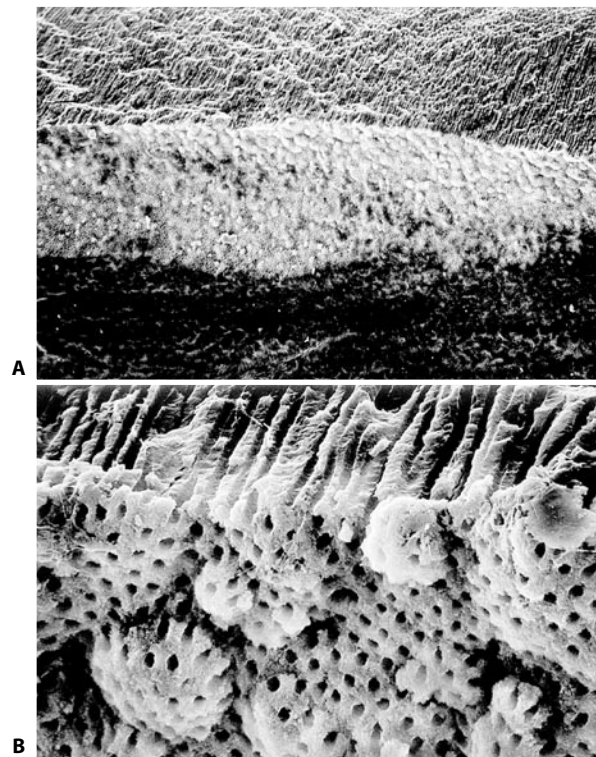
A. Middle one third of the distal root of a second lower molar, irrigated with NaClO, EDTA, and final rinse combined with ultrasonics. The area on the bottom has been prepared by the files, while in the upper area (near the fracture zone) the calcospherites of predentin are evident, to confirm that the instruments did not make contact with the dentinal walls (x110). B. At 1,000 magnifications it is evident that there is no organic material in the areas which have been cleaned but not shaped.
